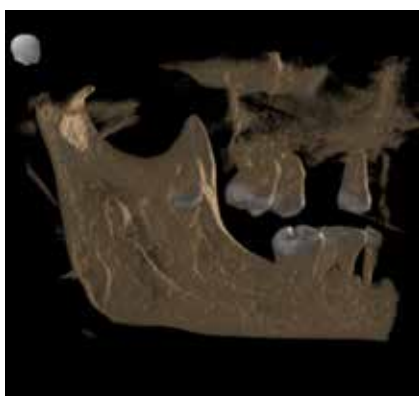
A Medial view of a CBCT reconstruction of the ectopic tooth in the left coronoid process
